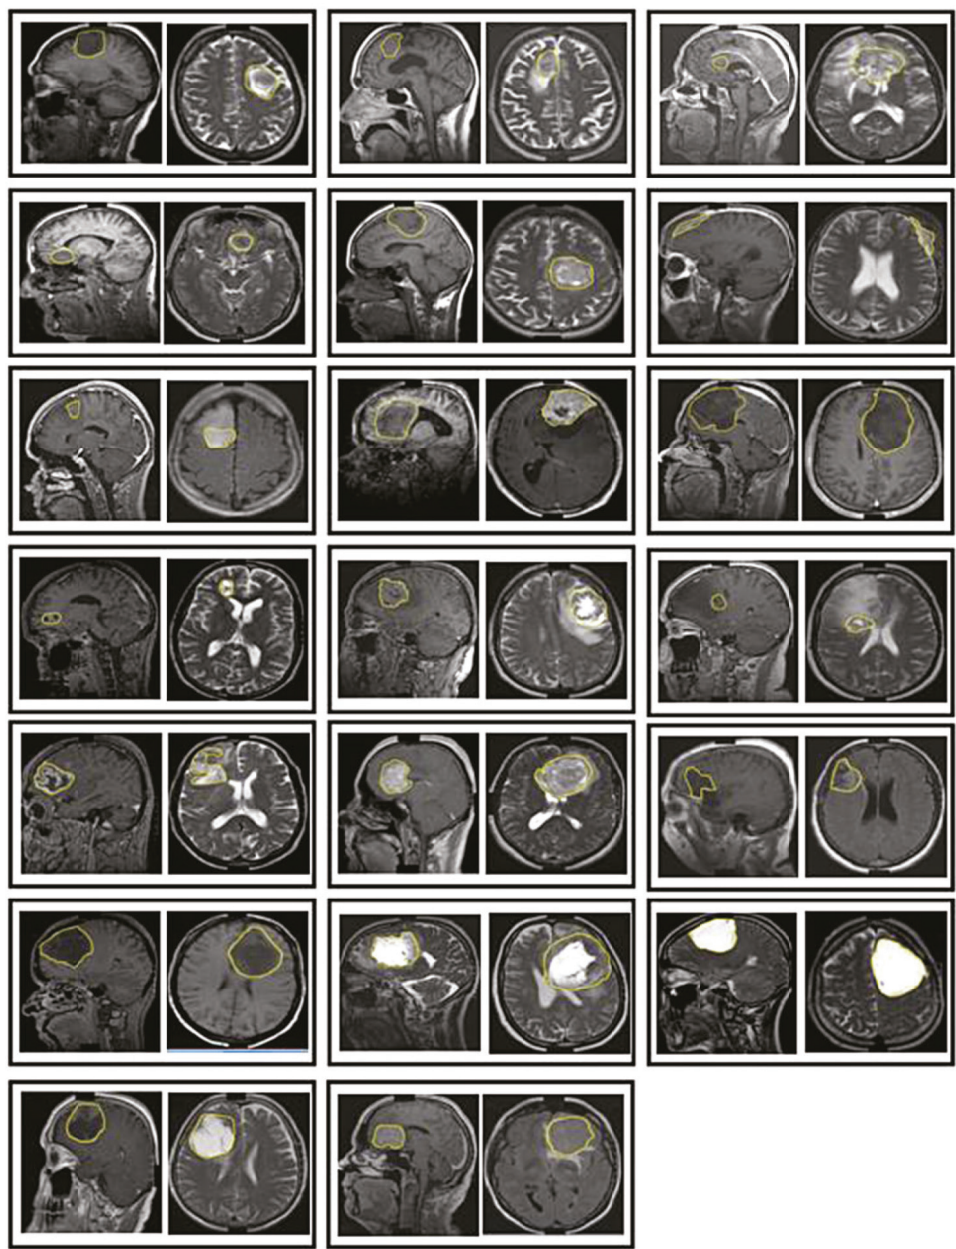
MRI images of tumour patients
